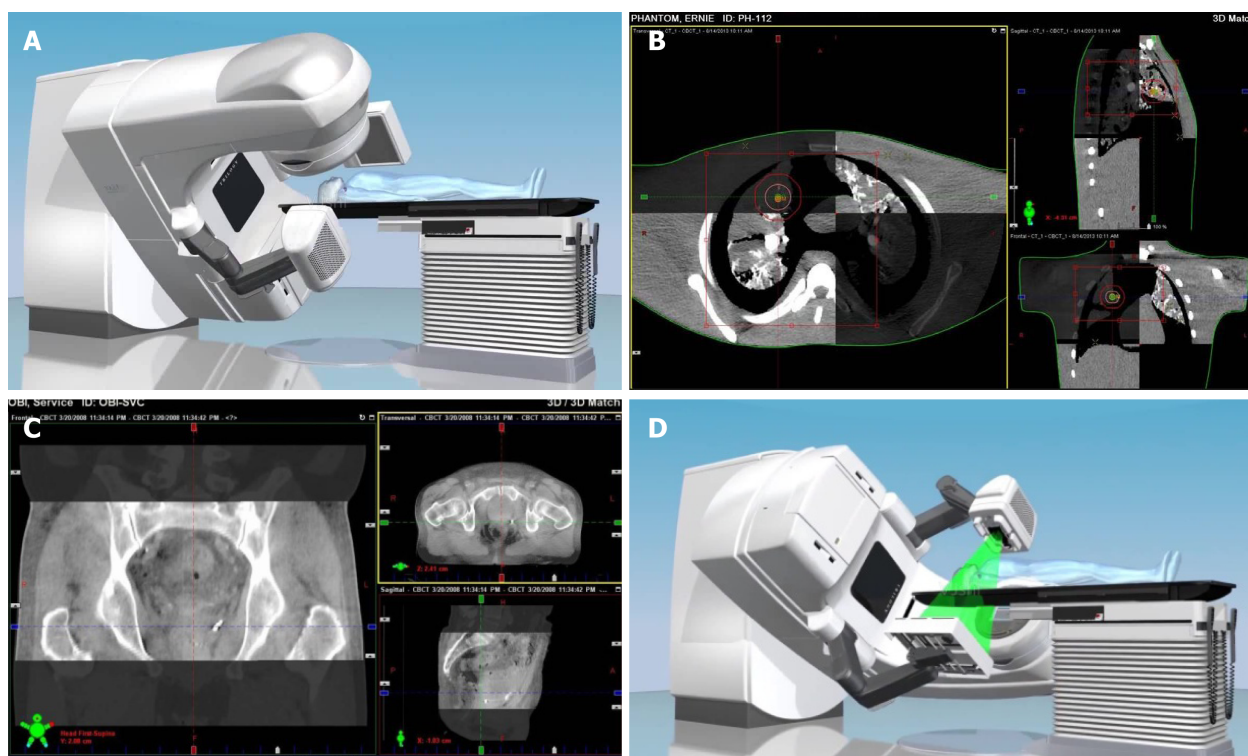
Images of computed tomography. A: The placement of cone beam computed tomography; B: Chest image fusion; C: Pelvic image fusion; D: Radiotherapy after correction with image-guided radiotherapy.
